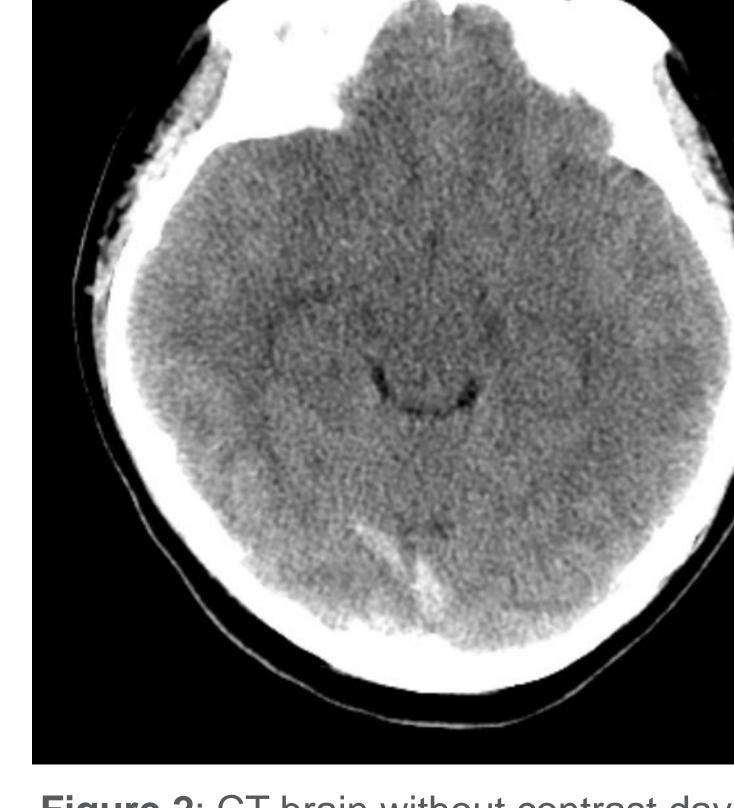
CT brain without contrast day 1
